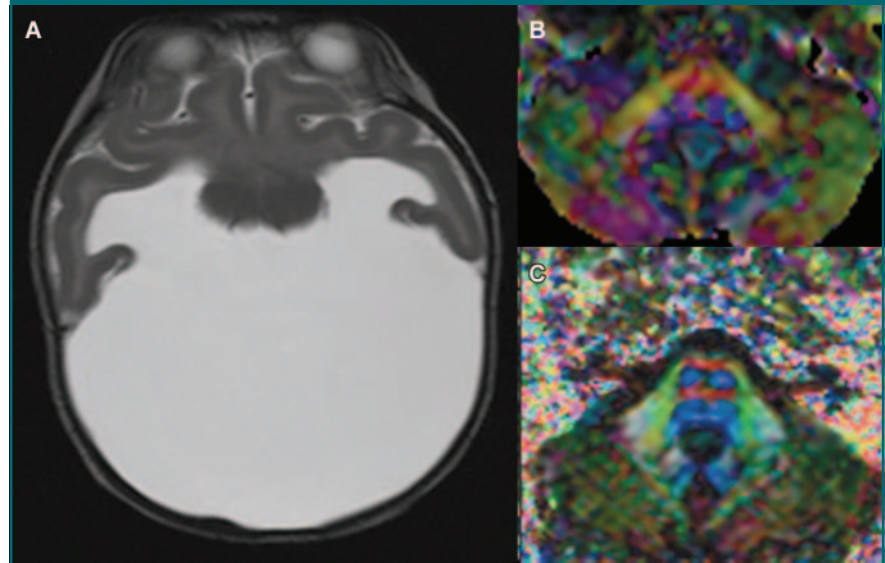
A, Transverse T2-weighted image (3000/20, 80) demonstrates alobar holoprosencephaly. B, Transverse color-encoded DT image depicts absence of corticospinal tracts (red, left to right; blue, cranial to caudal; green, anterior to posterior). C, Transverse color-encoded DT image depicts normal corticospinal tracts in healthy subject (DT imaging; six directions; b value, 600 sec/mm²; 5000–6000/92; matrix, 64 × 64; FOV, 120 × 120 mm; section thickness, 3 mm). (Reprinted, with permission, from reference 133.)
